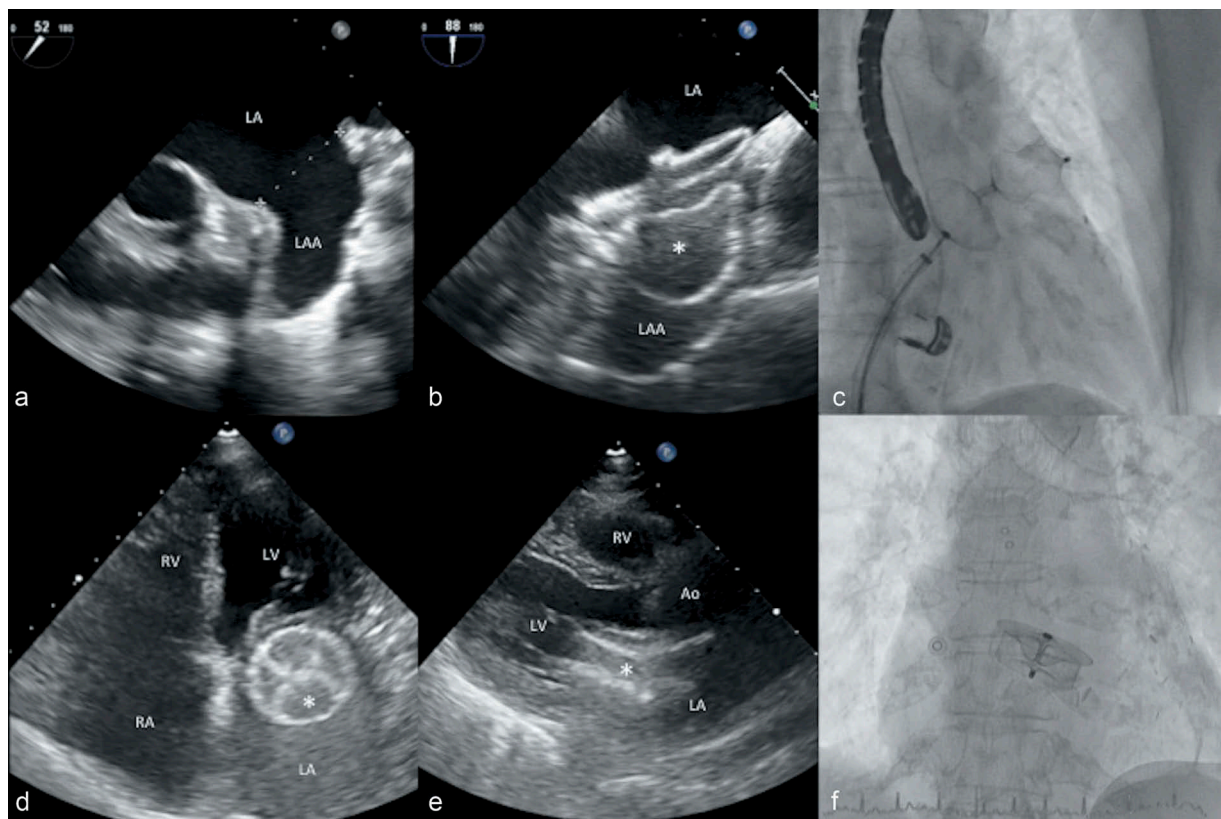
Pre- and post-LAA occluder placement images. (a) Transesophageal echocardiography (TEE) before device implantation. (b) TEE showing appropriate device placement. (c) Successful stability (tug) test during angiography face view (Online Video 1). Device dislocation on respectively (d) transthoracic apical 4-chamber view (Online Video 2), (e) transthoracic parasternal long axis view (Online Video 3), and (f) angiography face view (Online Video 4). Abbreviations: Ao, aorta; LA, left atrium; LAA, left atrial appendage; LV, left ventricle; RA, right atrium; RV, right ventricle; *LAA occluder.
